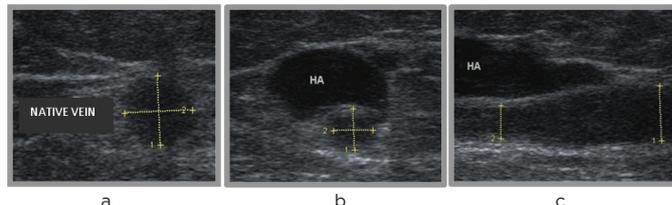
Ultrasound images, a) native vein in standing patient, b) vein compressed by hyaluronan (HA) prior to foam sclerotherapy, c) longitudinal view showing edge of HA compressed segment.
